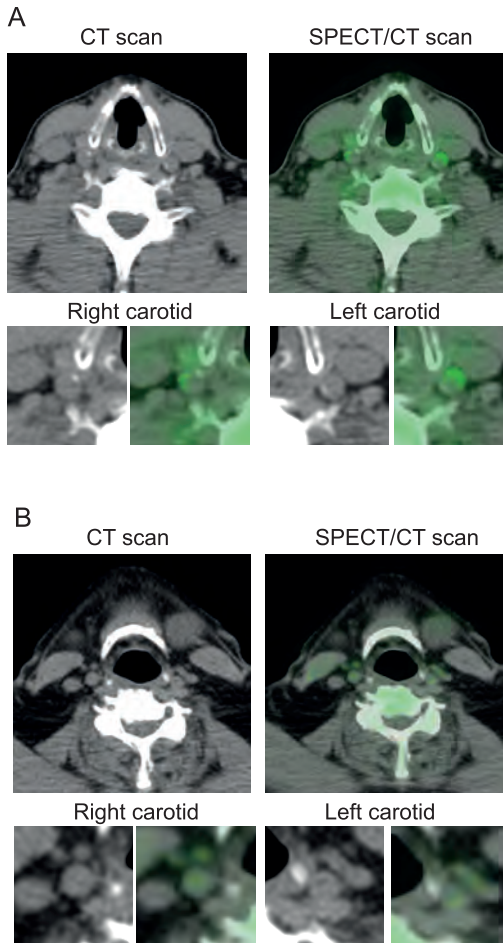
SPECT/CT of the carotids in a CV patient and control
